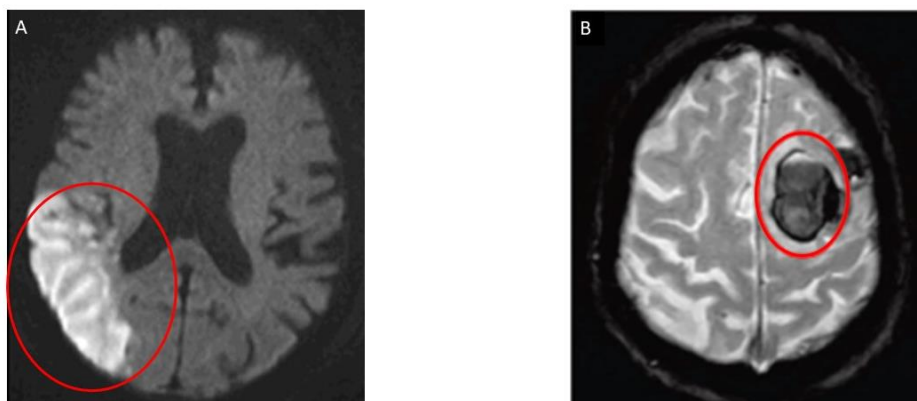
Dual-contrast magnetic resonance imaging (MRI) depicting two distinct types of stroke. A. Large right parietooccipital ischemic stroke. B. Sizeable left frontal hemorrhage (15).
